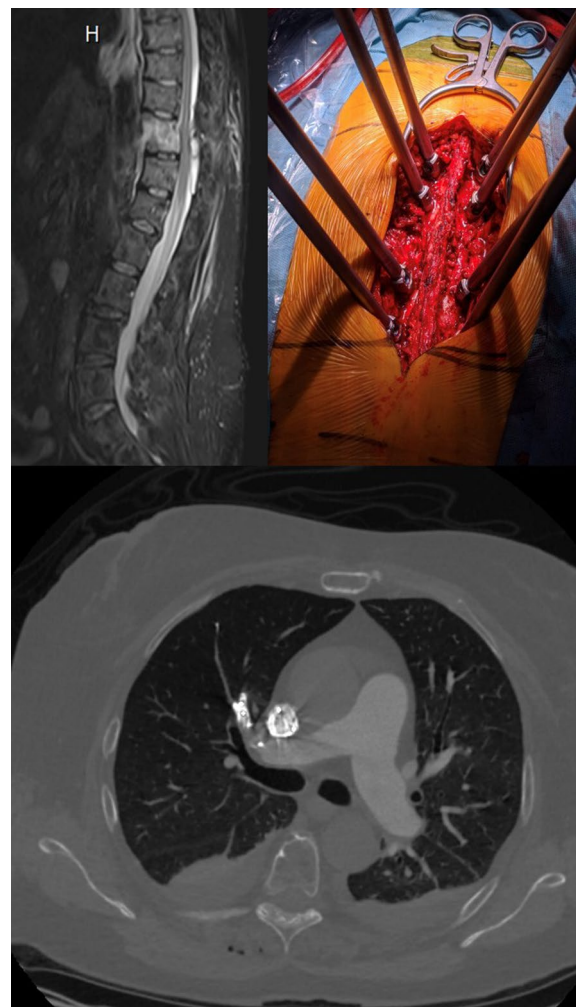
Figure (abstract P080) Chest CT with cement migration to the pulmonary vasculature
